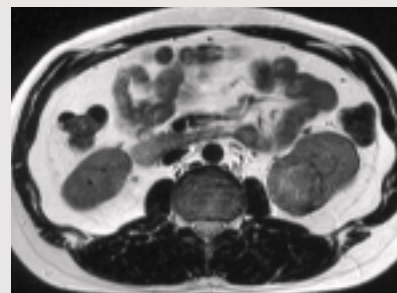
T2-weighted image
